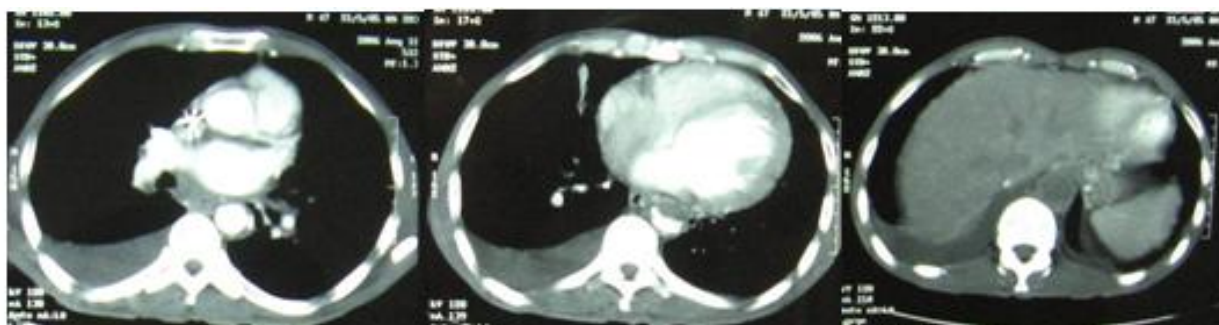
CT scan showing total occlusion of descending aorta at level of diaphragm.
